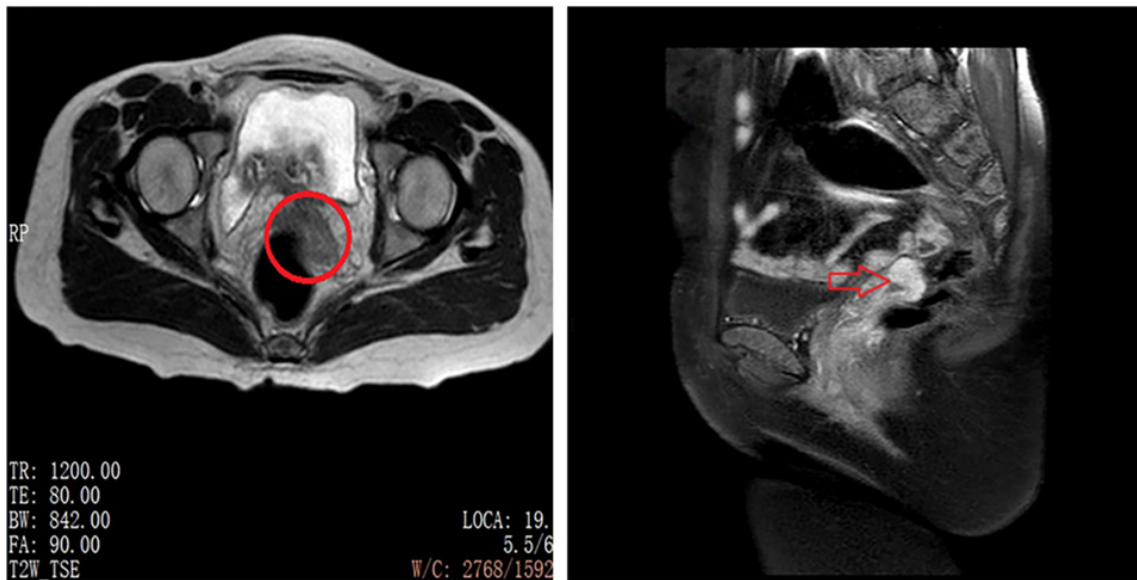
Post-contrast MRI demonstrating a punctate soft-tissue nodule along the left posterolateral aspect of the vaginal cuff. (A) The nodule exhibits mildly high signal intensity on axial T2-weighted imaging (red circle). (B) Marked enhancement on sagittal contrast-enhanced T1-weighted imaging is shown (red arrow). The lesion shows ill-defined margins with the vaginal wall, with slight irregularity of the outer vaginal contour. These imaging features are highly suggestive of a vaginal cuff malignancy.
